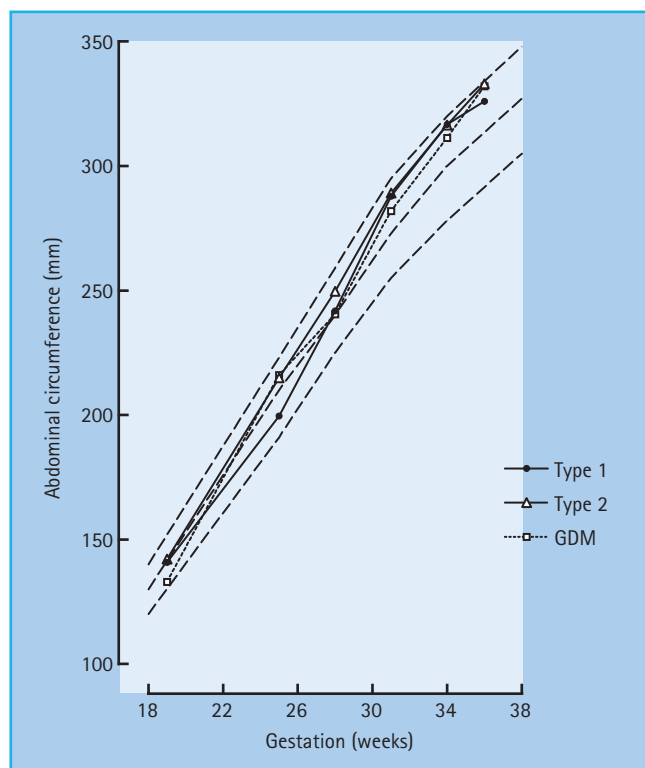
Similar rates of increase in fetal abdominal circumference in gestational diabetes (GDM) and pre-gestational diabetes as measured by ultrasound. Reproduced from Lim *et al.* [42], with permission from RSM Journals.
